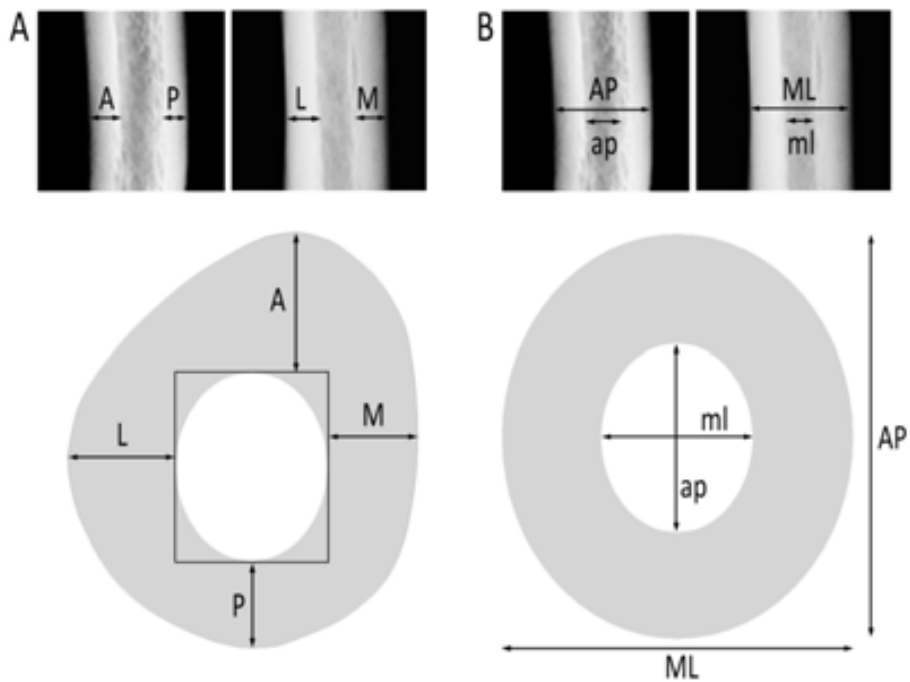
Reconstruction of diaphyseal cross-sections images. The section at 35% from the distal end of a human humerus is shown. A: Reconstruction of the medullary canal using the ellipse model method. Biplanar radiographs in the anteroposterior and mediolateral planes are used to measure the cortical thickness of the anterior (A), posterior (P), lateral (M) and lateral (L) aspects. The periosteal contour was obtained from a 3D image of the bone. B: Reconstruction of both the periosteal contour and the medullary canal using the ellipse model method. Biplanar radiographs in the anteroposterior and mediolateral planes are used to measure the anteroposterior (AP) and mediolateral (ML) diameters of the diaphysis and the anteroposterior (ap) and mediolateral (ml) diameter of the medullary canal. Adapted from O’Neill and Ruff (2004).
